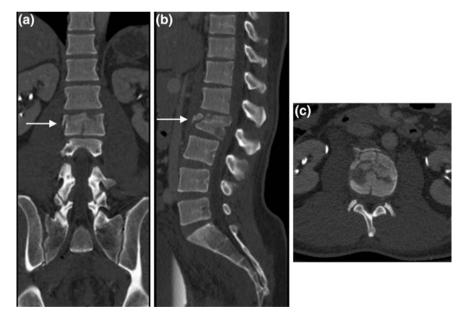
Spine protocol CT images. Multiplanar reformatted images from a spine protocol CT scan, in a sagittal, b colonal, and c axial planes, facilitate the extraction of detailed information regarding the vertebral fracture pattern and extent allowing a more accurate assessment for treatment planning
